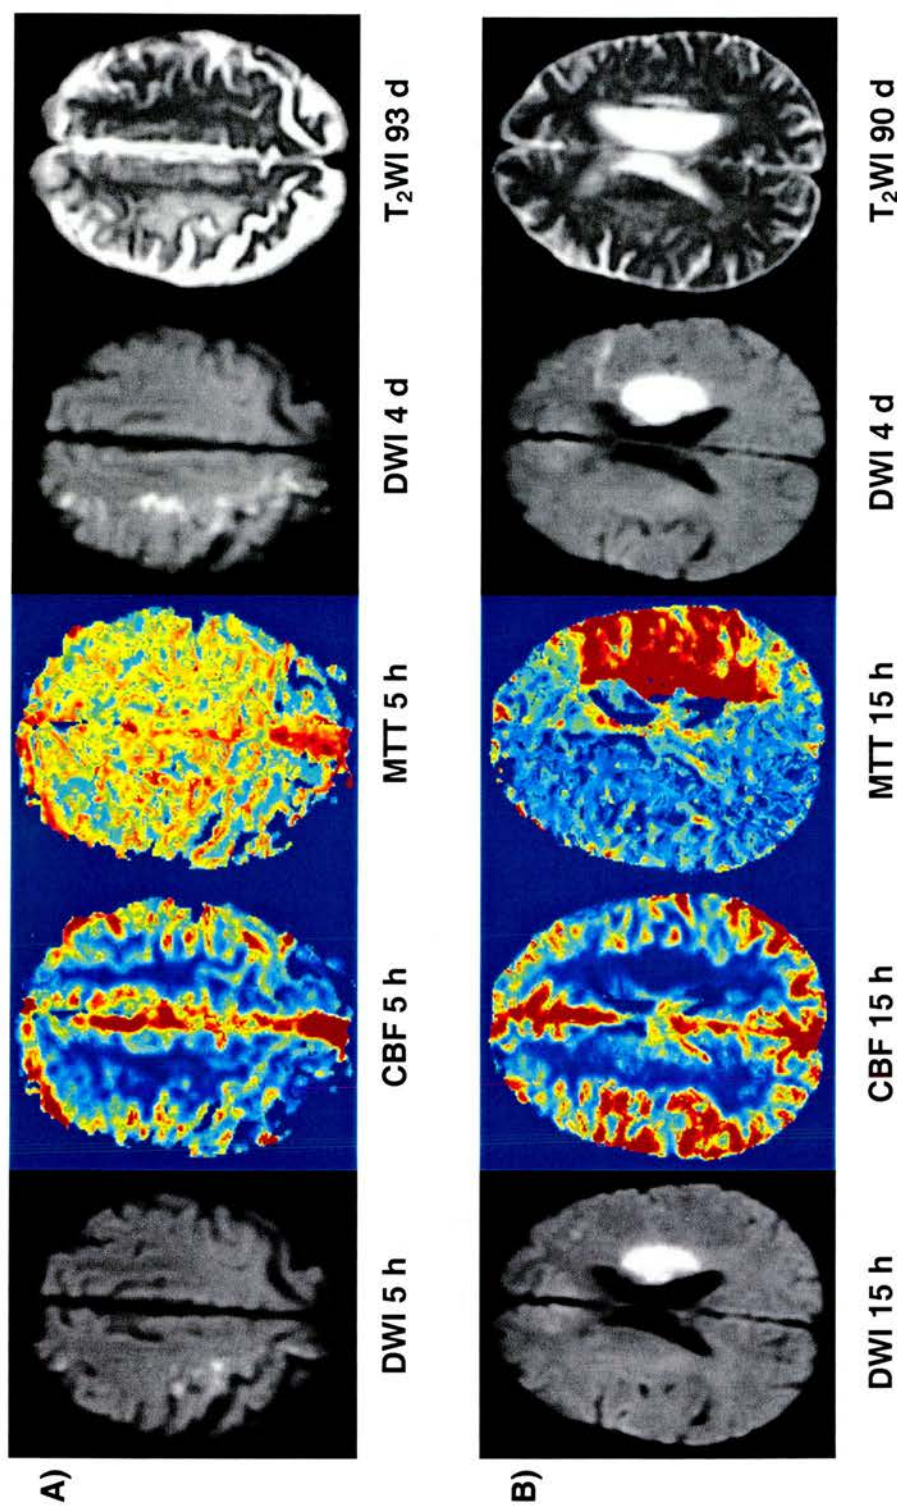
Examples of acute 'DWI/PWI mismatch'. A) a patient with a right hemisphere ischaemic lesion with no 'DWI/PWI mismatch' whose lesion grew between baseline DWI and final T₂WI; B) a patient with a left hemisphere ischaemic lesion and acute DWI/CBF and DWI/MTT mismatch, whose lesion did not grow between baseline DWI and final T₂WI. Note how MTT clearly overestimates, while CBF more closely matches, final lesion extent.
